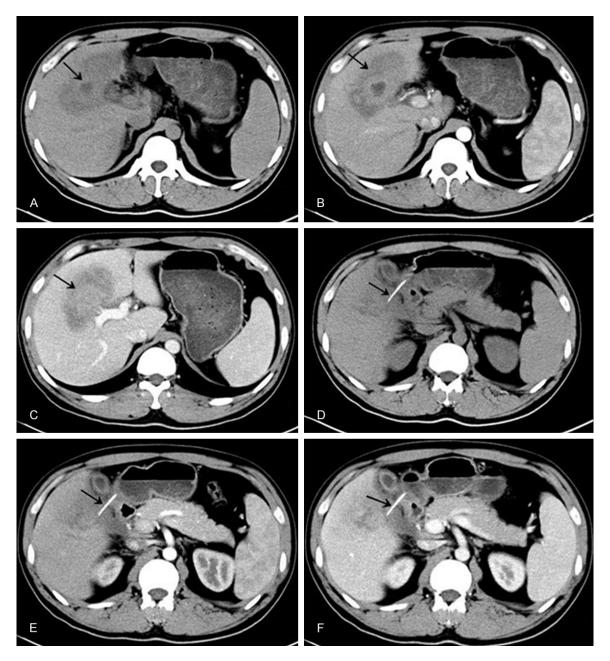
A-F: Abdominal CT scan revealing a circular low density area with circular enhancement in the right anterior lobe of the liver; an abscess was diagnosed. A high density shadow was observed outside the space between the duodenum and the liver.
